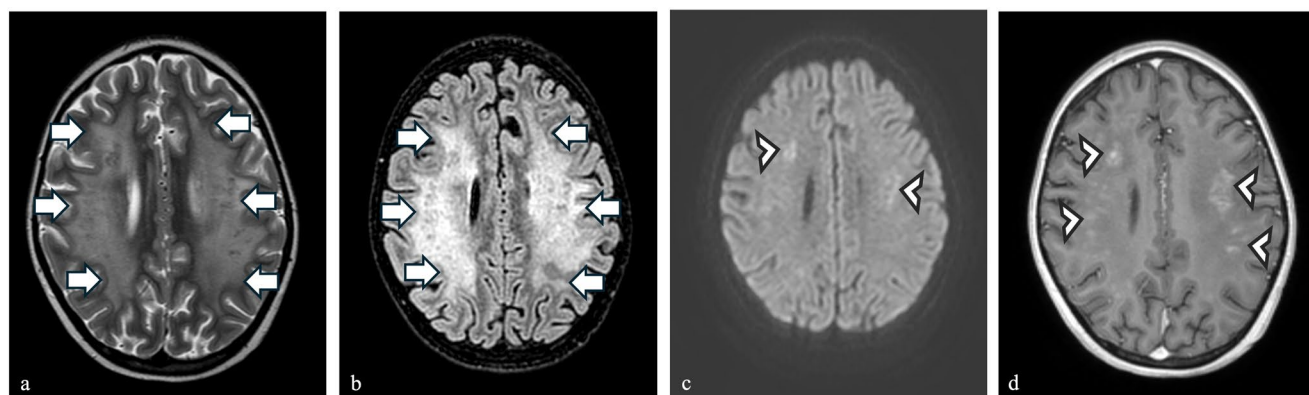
Ten-year-old boy with acute lymphoblastic leukemia under treatment with Chimeric Antigens Receptor Cells-T (CAR-T) therapy who developed psychomotor impairment. The MRI revealed large signal abnormalities in the white matter of the cerebral hemispheres (white arrows in the T2 TSE in a and in the FLAIR in b). Within these regions, multiple focal lesions characterized by restricted diffusion
